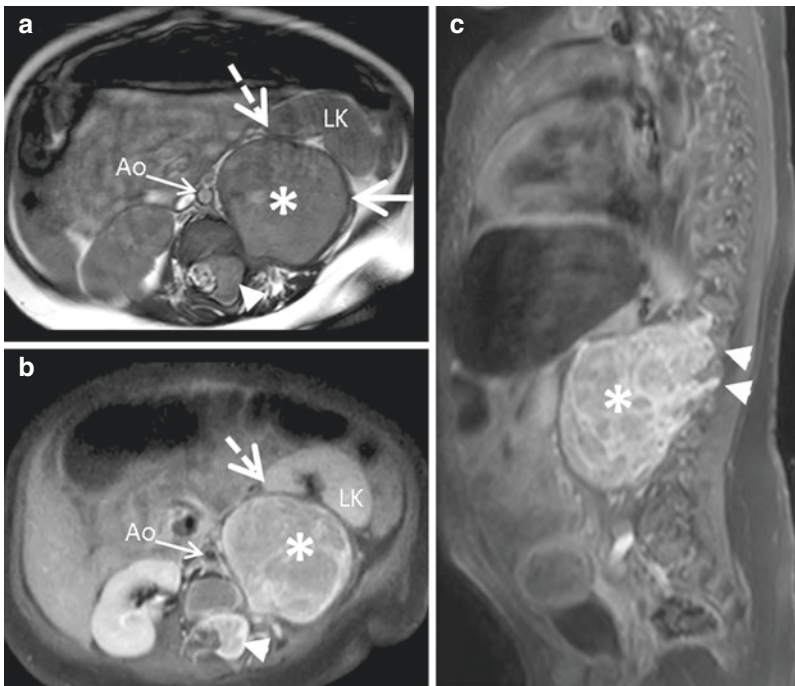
A 6-month-old girl with localized left lumbar neuroblastoma. MR transverse T2-weighted (a) and enhanced fat-saturated T1-weighted transverse (b) and sagittal (c) sequences show the tumor (asterisks) infiltrating the psoas muscle (IDRF, arrow), infiltrating the foramina and the spinal canal (50% in axial plane, i.e., IDRF, arrowheads), displacing the left kidney (LK) (dotted arrow) without infiltration (not IDRF), and separated from the aorta (Ao)
